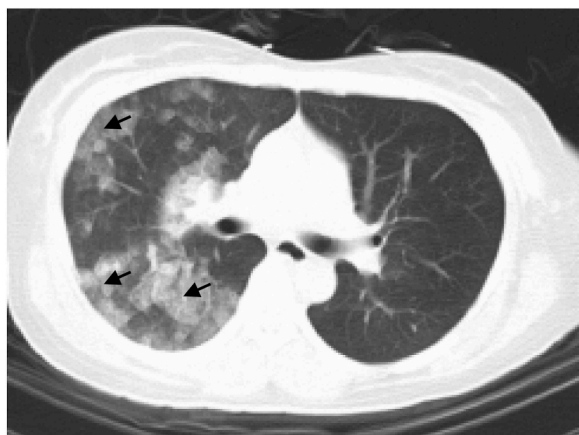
6 hours after the cholecystectomy procedure, a chest CT scan revealed DAH, with the right side being particularly evident.
